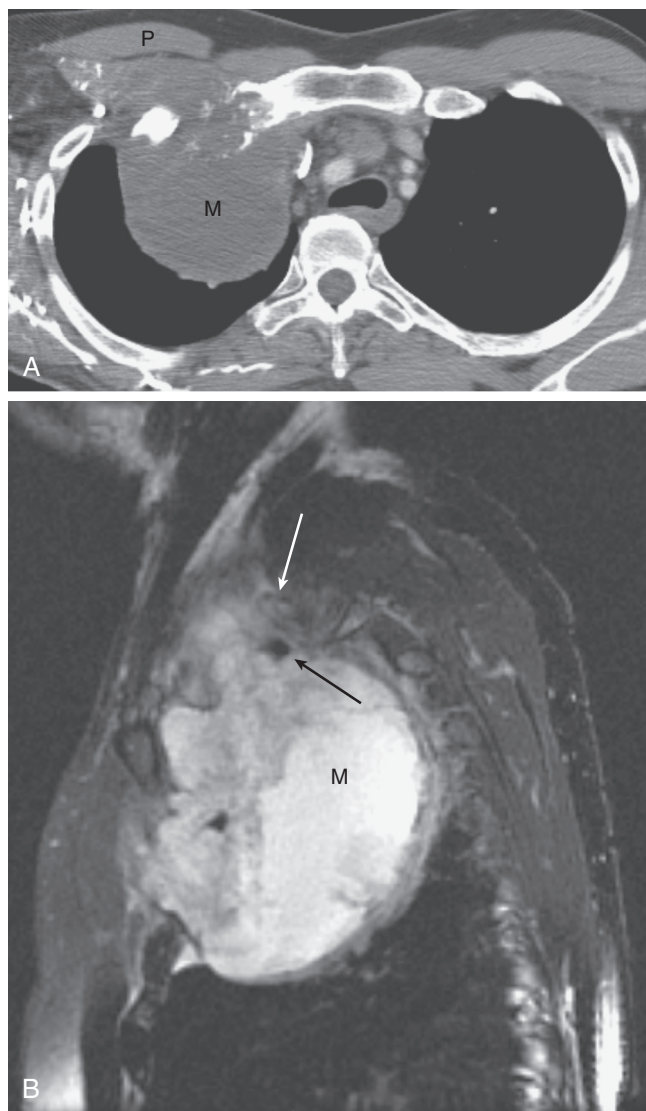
■ A 60-year-old man with newly diagnosed chondrosarcoma of the first rib presented with right shoulder pain. A, Contrast-enhanced axial chest computed tomography shows a large mass (M) arising from the right first rib. Note that the density of the mass is similar to that of muscle, as compared with the right pectoralis major muscle (P). The brachial plexus cannot be visualized. B, T2-weighted sagittal magnetic resonance imaging distinguishes the intensity of the mass (M) from that of surrounding soft tissues and muscles. This enables direct visualization of the right subclavian artery (black arrow) and brachial plexus (two black dots abutting tip of white arrow), which are surrounded by the tumor.
